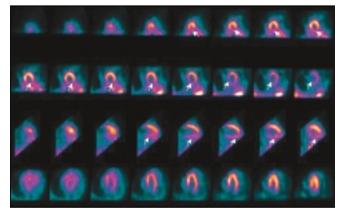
Resting thallium study reveals a large inferior and inferolateral defect on thallium uptake (white arrows). Figure 3. Photographs of transesophageal echocardiographic images showing a large coronary artery pseudoaneurysm compressing the right atrium and right ventricle (A) and predominantly systolic flow into the pseudoaneurysm on color flow (B) and pulsed-wave Doppler (C).
